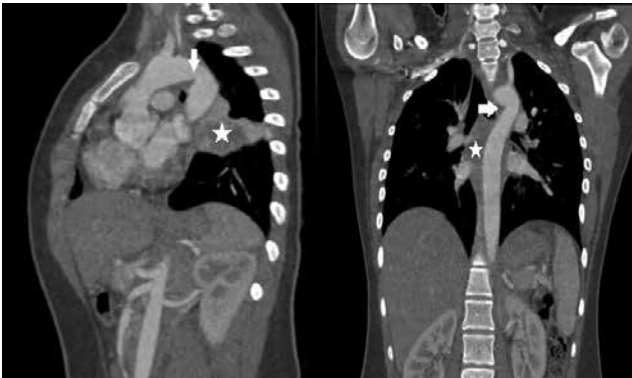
Computed tomography image revealed a pseudocoarctation with limited poststenotic dilatation of the descending thoracic aorta and the descending aorta pushed through the right hemithorax without intravascular extension.
